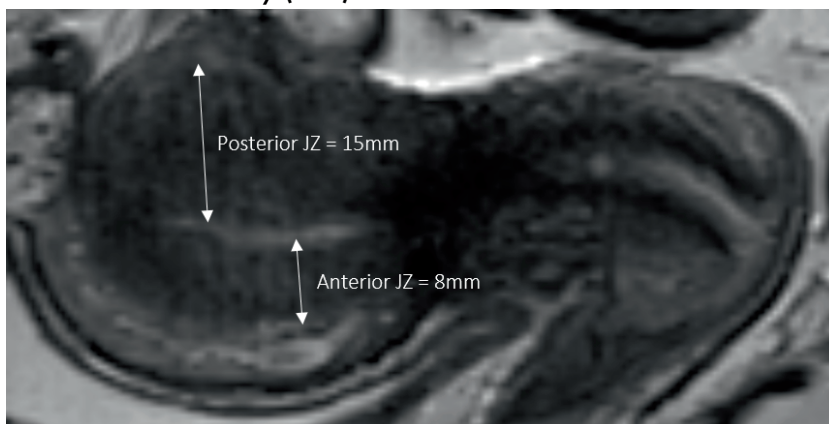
Sagittal T2W MRI showing junctional zone (JZ) asymmetry of the anterior and posterior walls, with a JZ differential (JZ Diff) > 5mm
